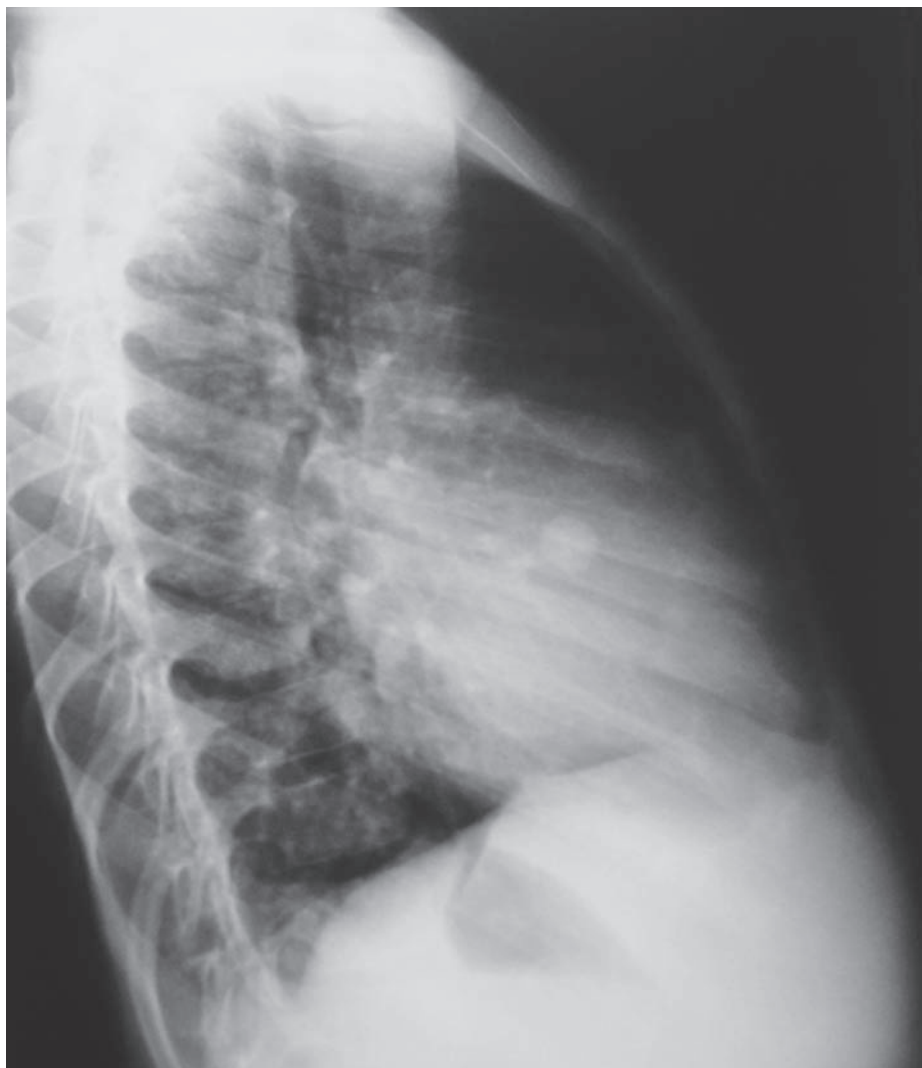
Chest radiography: pulmonary metastases
